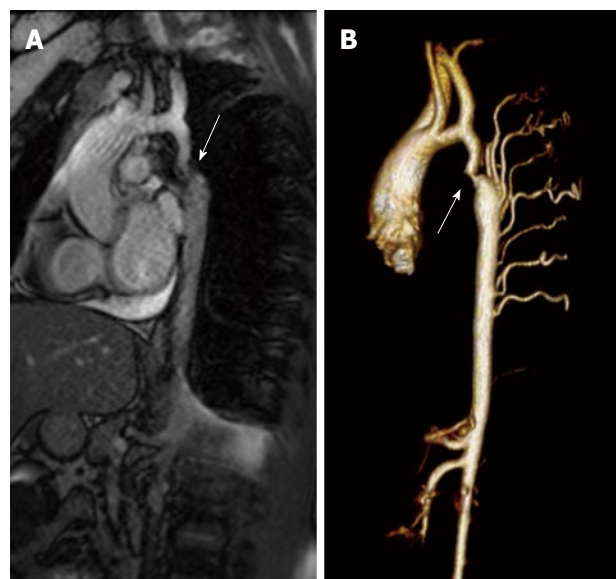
Magnetic resonance imaging of coarctation. A: Magnetic resonance image (steady-state free precession) in a sagittal projection demonstrating transverse arch hypoplasia and long segment coarctation of the aorta distal to the left subclavian artery (arrow) in a 12-year-old male; B: Three-dimensional reconstruction of a gated contrasted angiogram for the same patient, which demonstrates transverse arch hypoplasia, coarctation at the aorta at the distal transverse aortic arch and isthmus (arrow), and dilated intercostal arteries (collaterals).
